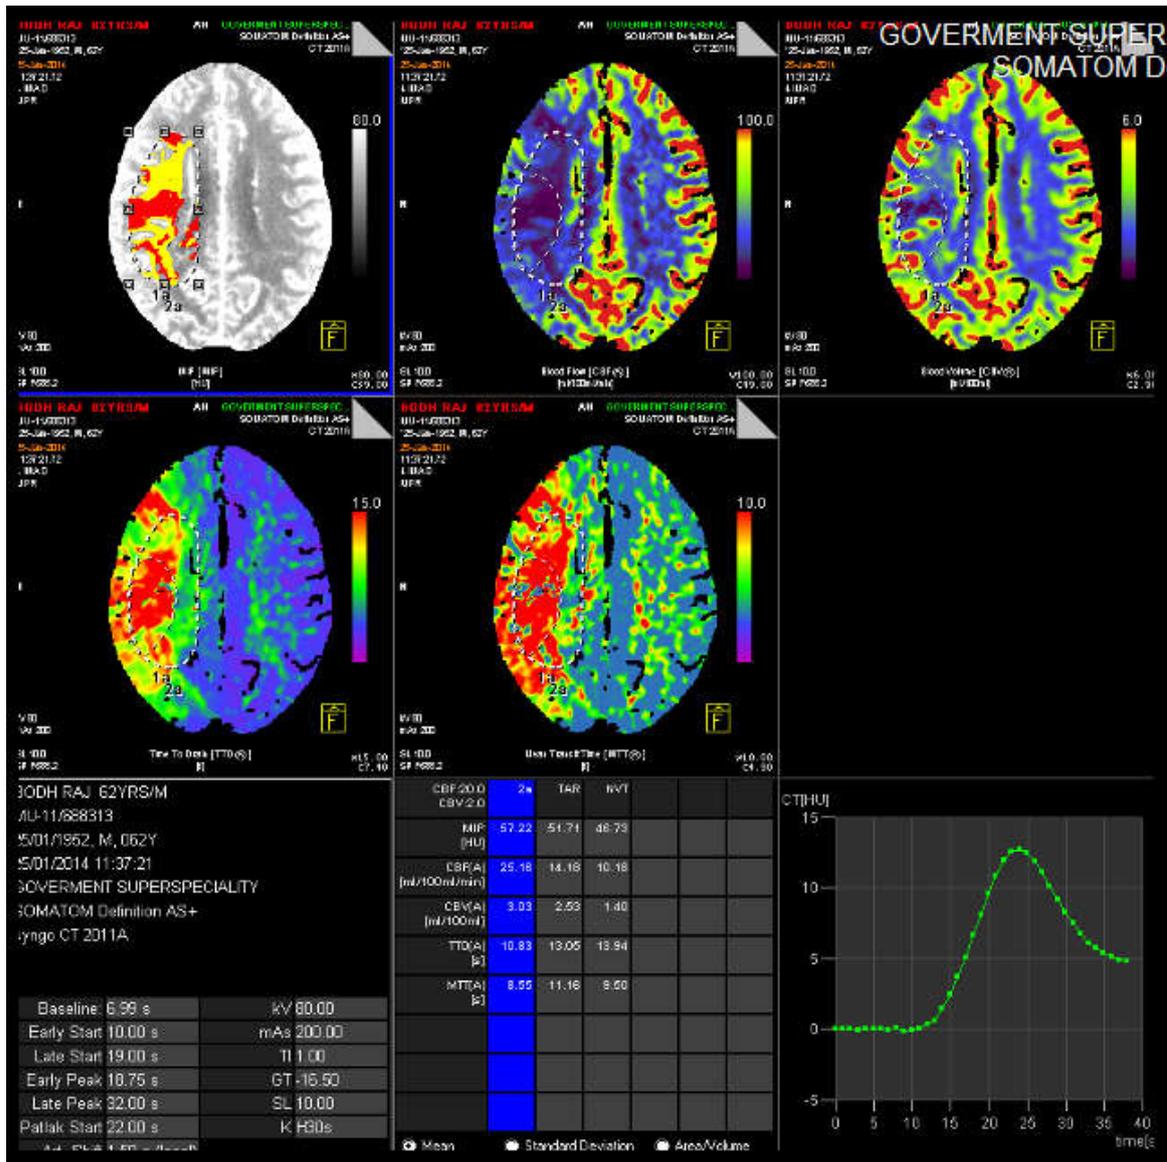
(b):- CT Perfusion of the same patient showing Perfusion deficit on all the perfusion maps with significant amount of penumbra seen on summary map in Right MCA territory. The Perfusion parameters for tissue at risk and core infarct are shown in the table.
